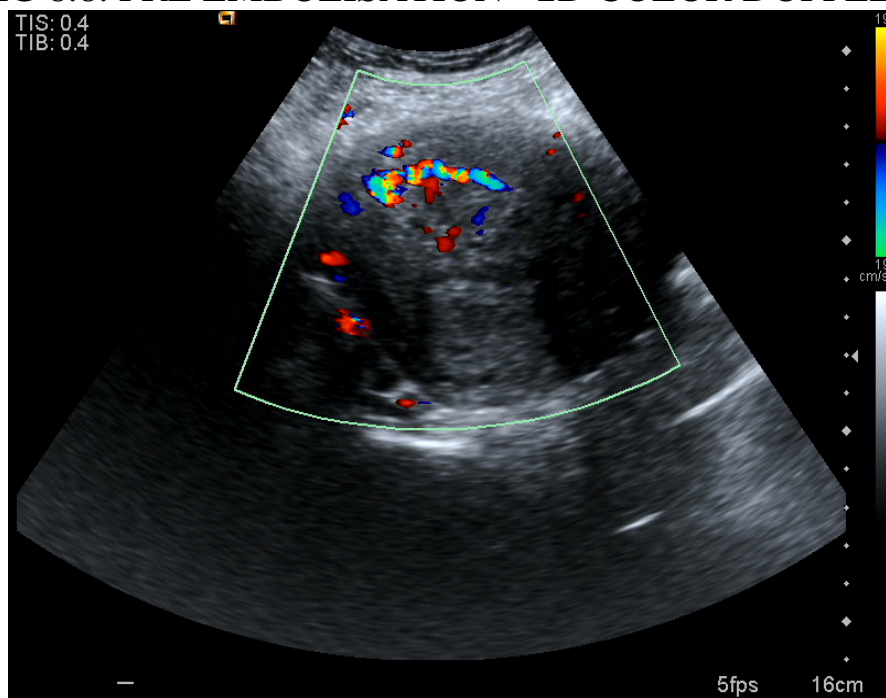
POST EMBOLISATION ULTRASONOGRAPHY
